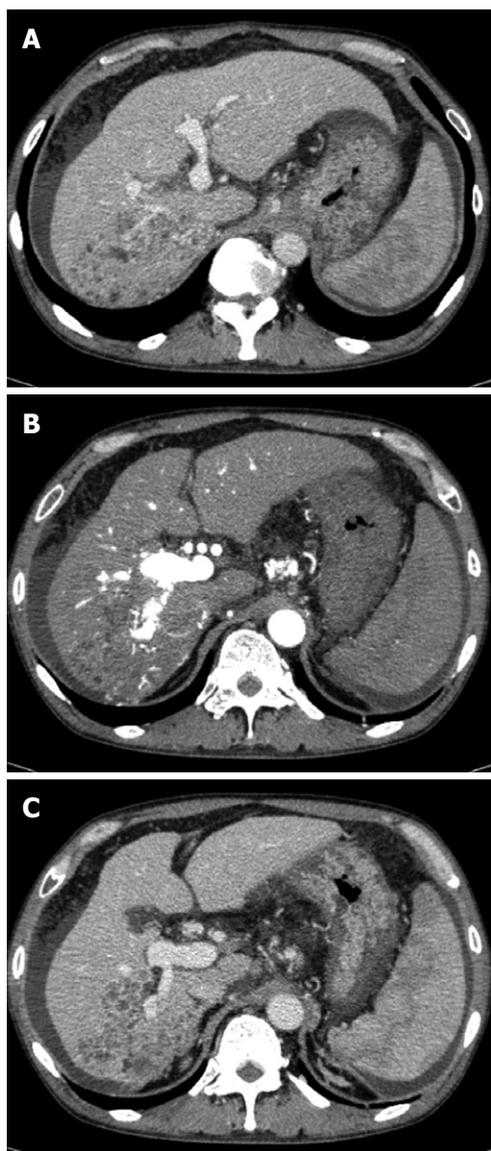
Computed tomography examination. A: Low-density lesion in the posterior segment of the liver, which pressed the vena cava and right hepatic vein and opposed the right anterior superior portal vein; B: Hyper-enhanced portal vein during the arterial phase; C: Tumor thrombus in the posterior branch of the portal vein. A tumor opposed the right anterior inferior portal vein.
